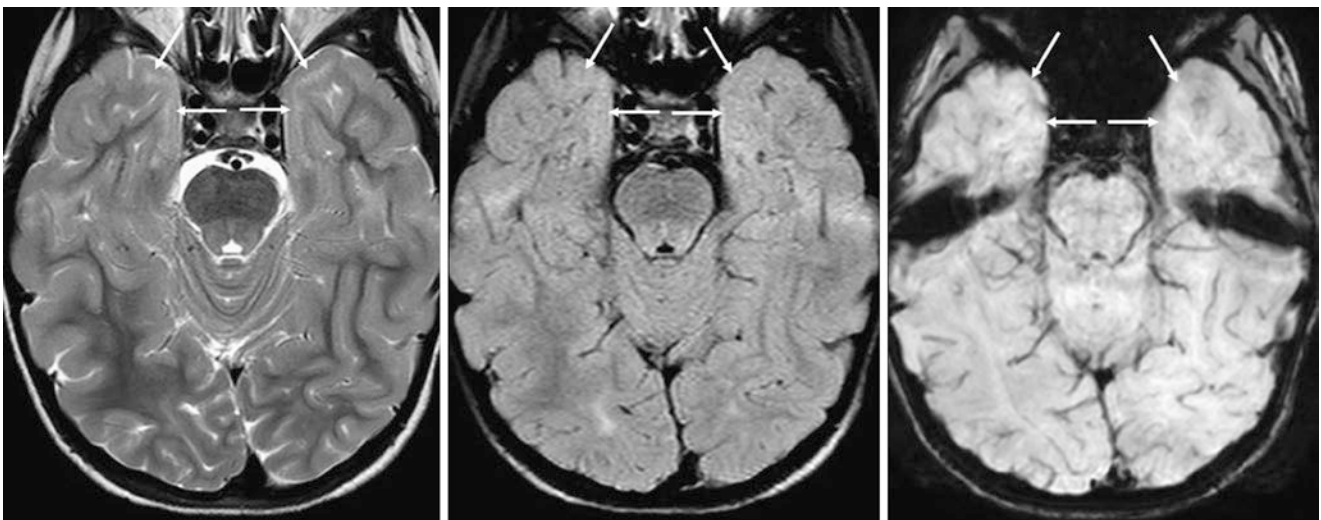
A 5.75-year-old with migraines. 3T SE T2WI (left), 2D FLAIR (middle), and SWI (right) were normal. Note terminal zones within the anterior temporal SCWM bilaterally (thin arrows), being slightly hyperintense on T2WI and not visualized on FLAIR. On SWI (right), there is no hemorrhage, so the condition is likely not related to remote trauma or other insult
